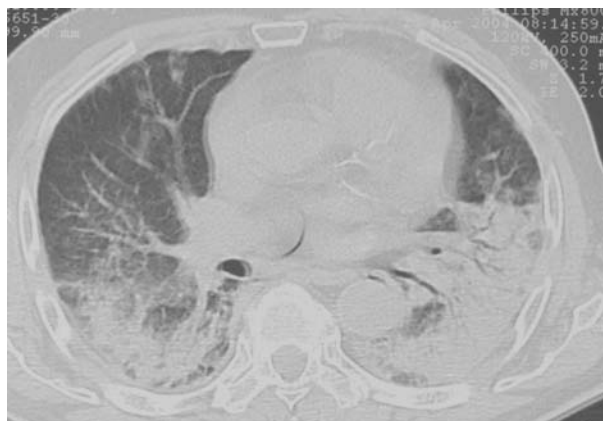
HRCT scan showing areas of ground glass attenuation and alveolar consolidation, mainly involving the lower lobes (Patient n. 17).
